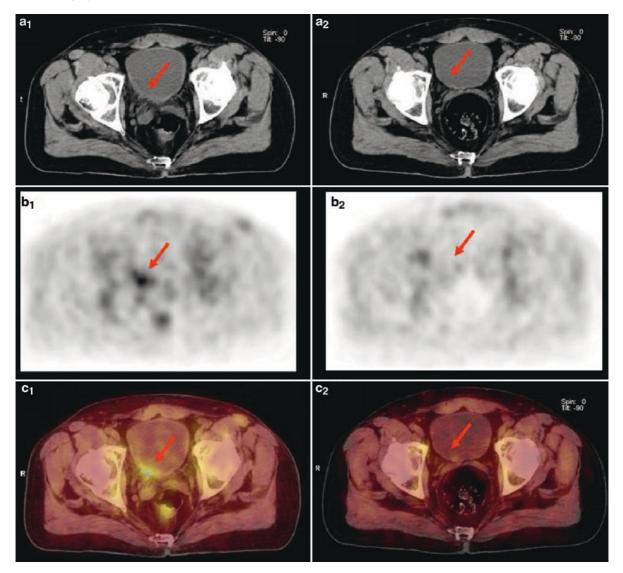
Transaxial CT (a), CHOL PET (b) and respective PET/CT fusion (c) images of a patient with bladder cancer prior to and after chemotherapy with six cycles of a combination of paclitaxel, carboplatin, and gemcitabine. Before treatment (1), enhanced CHOL uptake is noted in an area of bladder wall thickening (red arrows) indicating tumor tissue on CT. After treatment (2), CHOL uptake has normalized and CT shows a normal thickness of the bladder wall, indicating that CHOL PET has potential to monitor chemotherapy of bladder cancer
